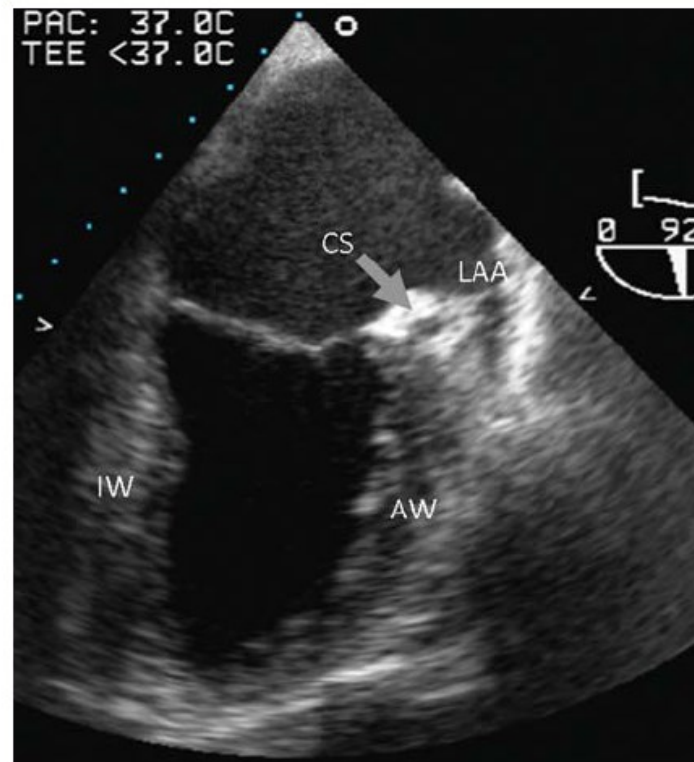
Transoesophageal two-chamber view. AW, anterior wall; IW, inferior wall; LAA, left atrial appendage; CS, coronary sinus.
